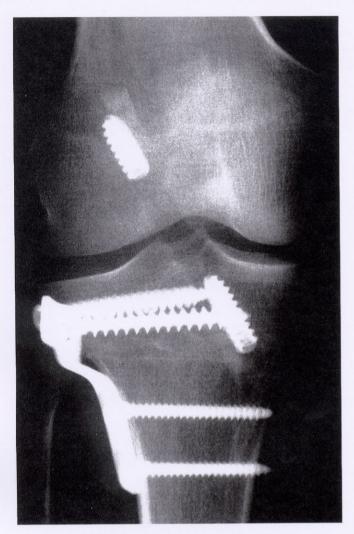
Four-month postoperative anteroposterior radiograph of a patient after ACL reconstruction and concomitant high tibial osteotomy for varus deformity in preparation for second stage ACI to treat a symptomatic focal chondral defect of the medial femoral condyle.
